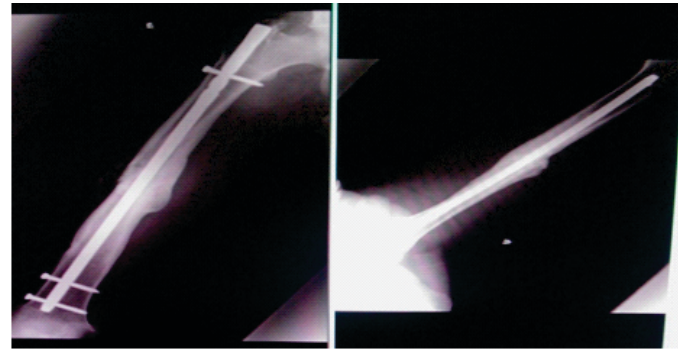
AP and lateral X-ray of same patient (Fig 6) after revision nail and bone grafting helped solid union. Proximal static locking bolt was removed to dynamize the nail after 2 months.
